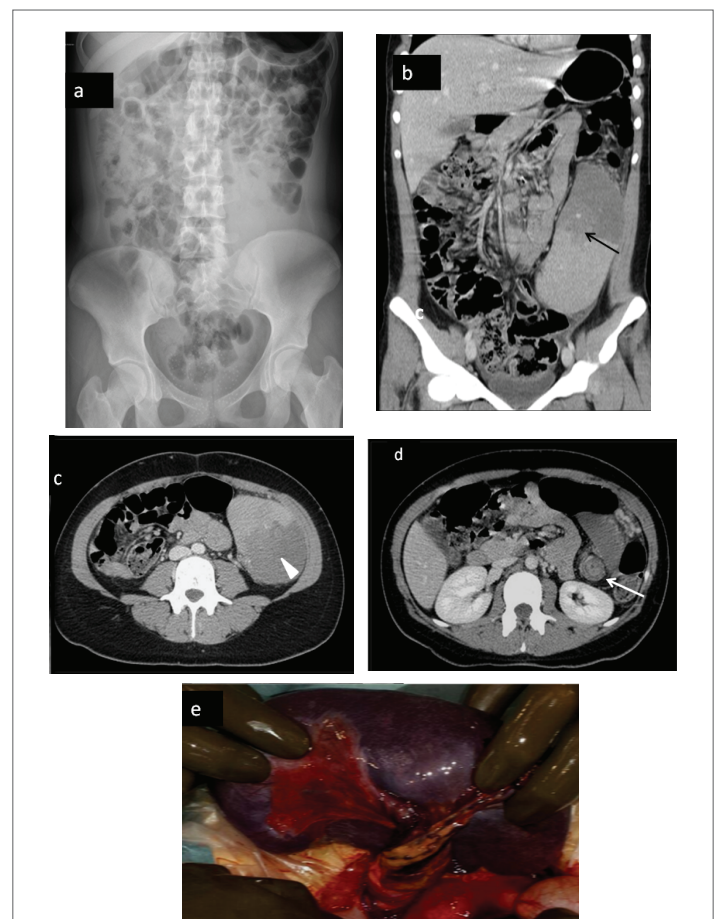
a) Abdominal X-Ray: displacement of the bowel and lack of gas on left low quadrant
